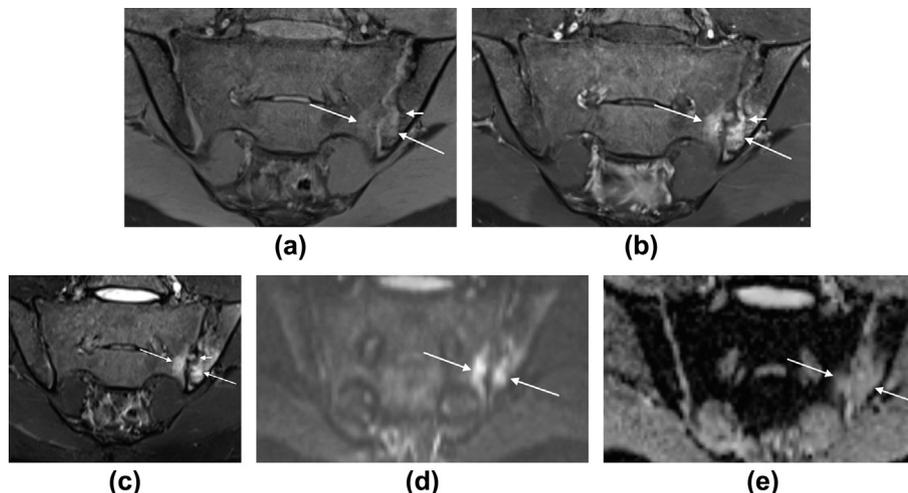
A 17-year-old male patient undergoing MRI for suspected sacroiliitis with MRI findings of active disease including erosion and oedema. T1 fat saturated pre- (a) and post-contrast (b) and STIR (c) images demonstrate broad-based erosion on the iliac side of the left sacroiliac joint (short arrow on all images). There is surrounding oedema on both sides of the joint (long arrows on all images) with enhancement in keeping with osteitis. (d) High b-value DWI image demonstrates high signal in the region of the previously mentioned oedema without a corresponding low ADC value (e), in keeping with free diffusion.
